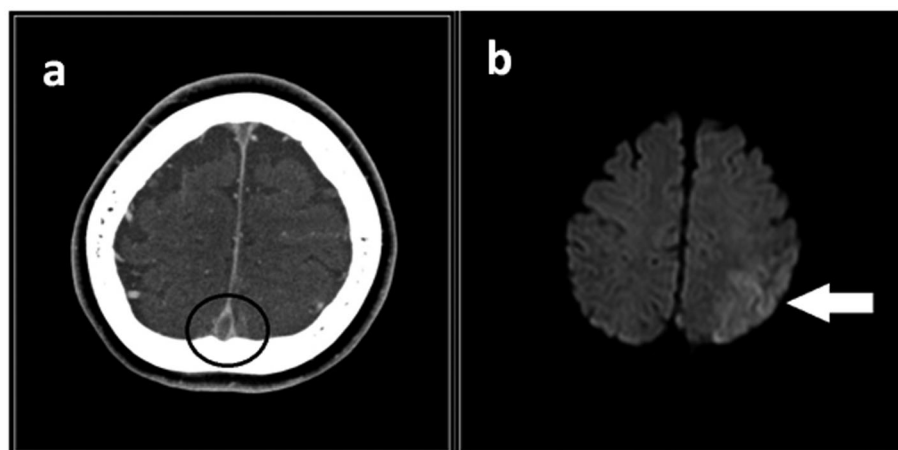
a: Loss of contrast (empty delta sign) is observed on contrast CT (delay) (inside the circle). b: MRI FLAIR image: High signal findings are observed in the left parietal lobe, indicating edematous changes and cortical infarct (arrow).
